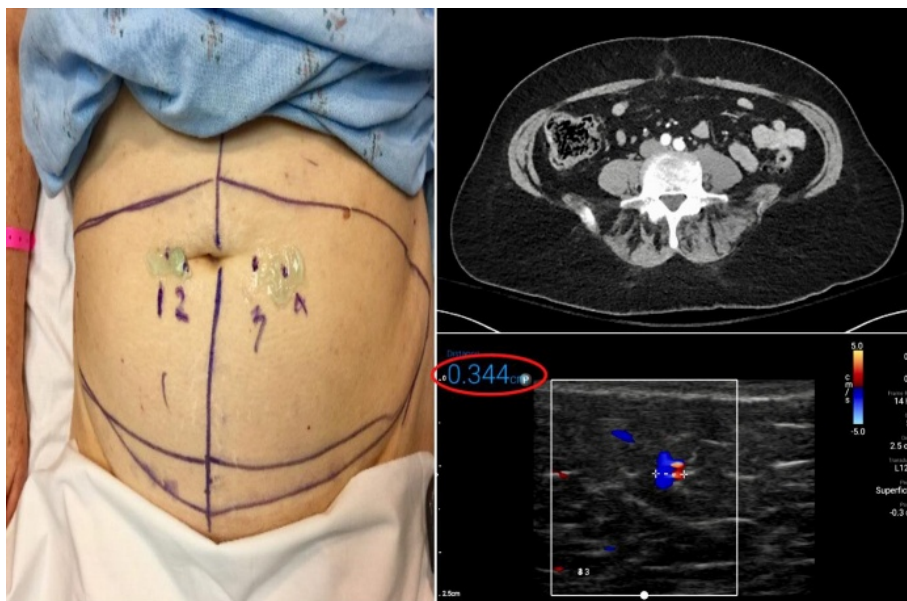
Left, Preoperative markings of perforator "hot spots" as identified by handheld, pencil Doppler. Top, Computed tomography angiography fails to identify a perforator at position 3 (3 cm left of patient's umbilicus). Bottom, Color Doppler ultrasound properly identifies a perforating artery-vein (3.44 mm) at position 3 that was ultimately utilized as the dominant DIEP intraoperatively.
